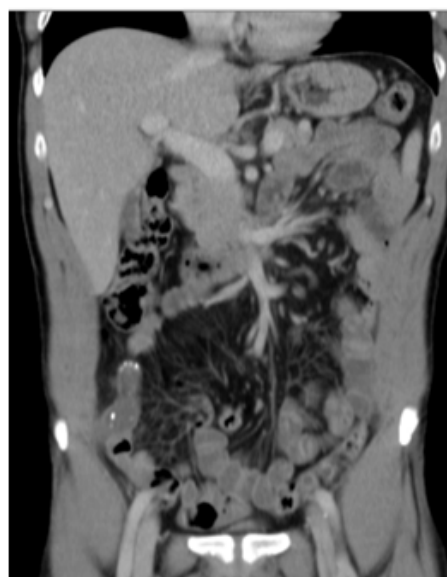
Coronal CT scan image showing a dilated appendix measuring up to 2.1 cm with mild inflammatory periappendiceal fat stranding and calcification.
